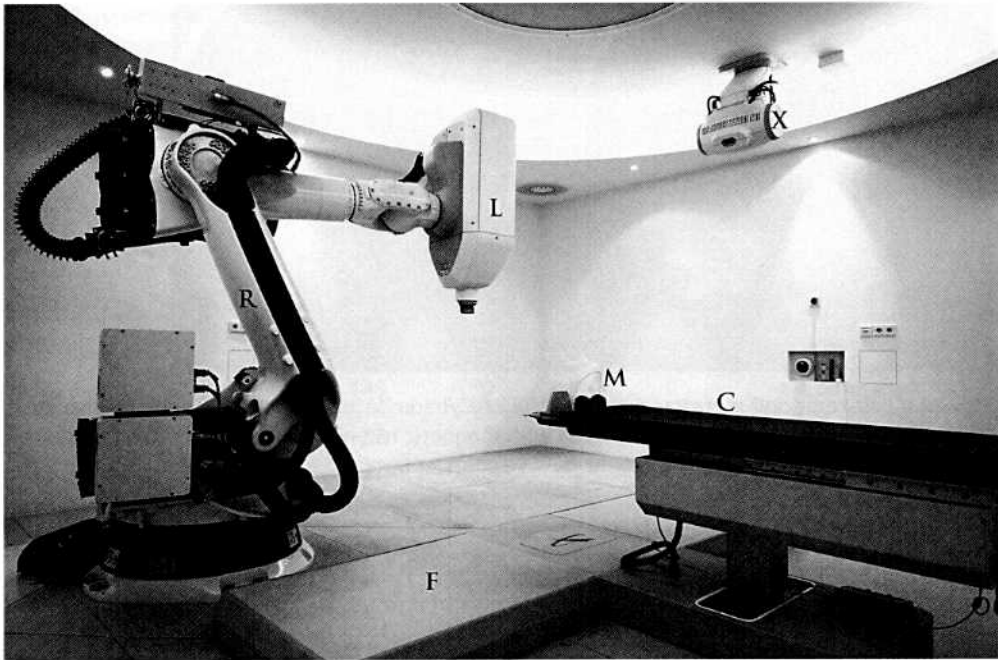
The CyberKnife System and its components. C = patient couch; M = head support and the thermoplastic mask; X = X-ray tube; F = X-ray detectors; R = robotic arm; L = linear accelerator.
